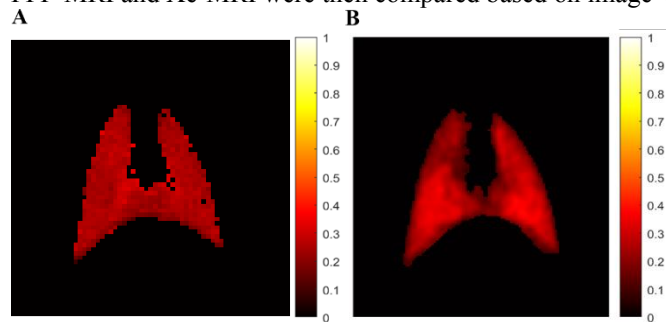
A: FV map extracted from MBW Xe-MRI. Mean FV=0.22 \pm 0.03. B: FV map extracted from MBW PFP-MRI. Mean FV=0.24 \pm 0.07.
